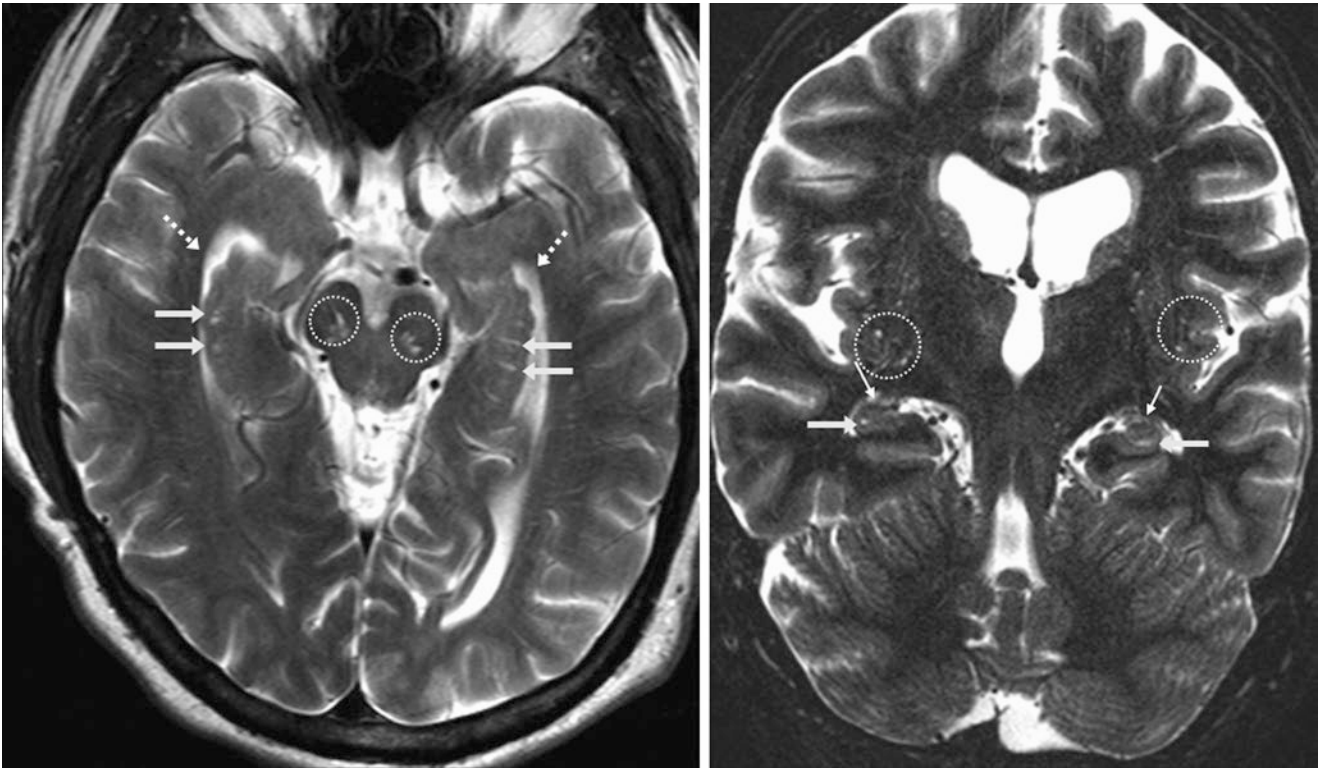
A 60 year old underwent axial (*left*) and coronal (*right*) T2WIs from a 1.5 T MRI that demonstrated hippocampal cysts bilaterally (*arrows*), located medial to the lateral ventricles' temporal horns (*dashed arrows*). On the coronal image, note the choroidal fissures (*thin*
